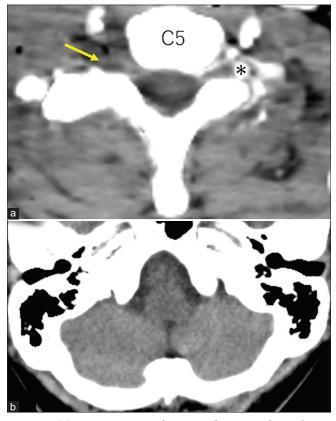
(a) Post-contrast axial computed tomography at the C5 level showing crushed paraspinal soft tissues around the right C4/5 intervertebral foramen with unclear delineation of the right vertebral artery (arrow). No extravasation of contrast agent is observed. (b) Non-contrast axial computed tomography of the head showing no abnormal findings in the lower cerebellum. Asterisk: Left vertebral artery.
